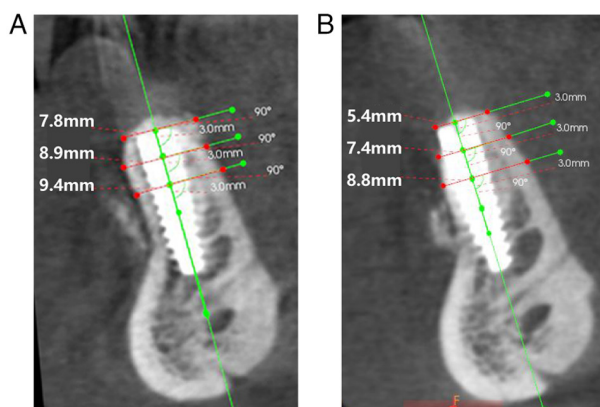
Bone width assessment by cone-beam computed tomography after implant insertion. (A) Immediately and (B) 6 months after implant insertion.
